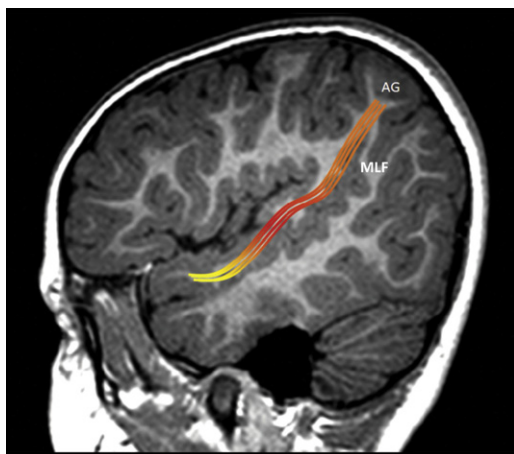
MR image showing middle longitudinal fasciculus (MLF) extending from inferior parietal lobule to temporal pole. AG, angular gyrus.
